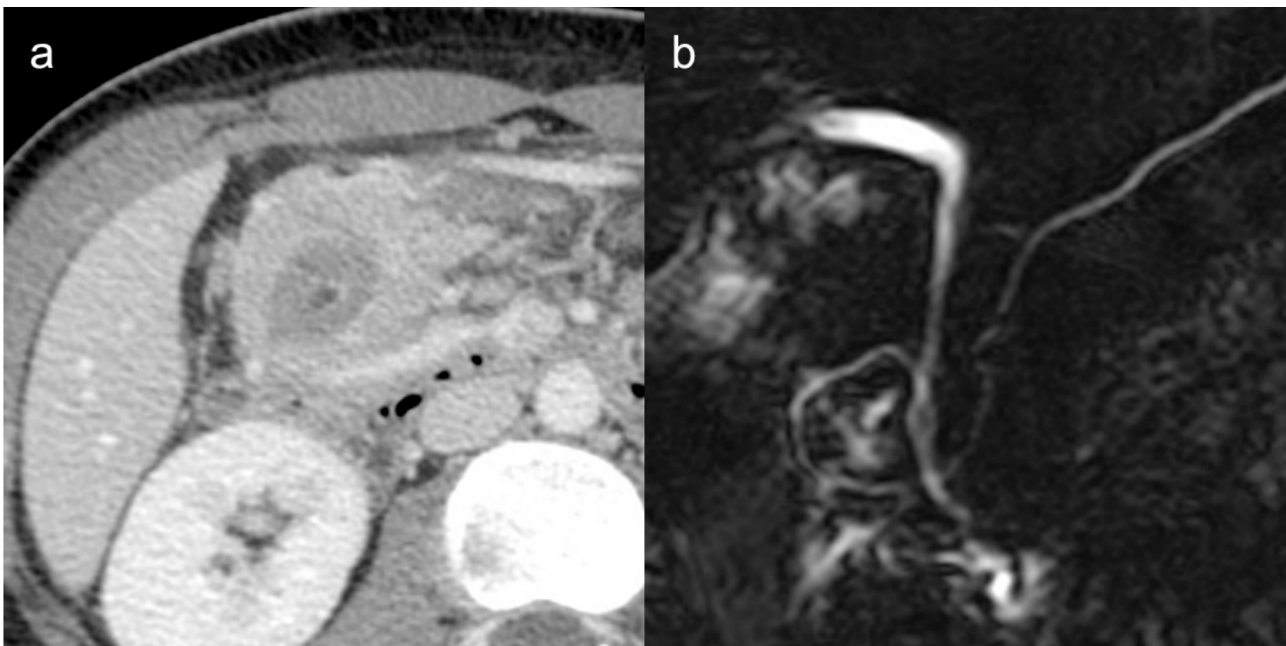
48-year-old male with annular pancreas. Contrast-enhanced CT (a) show the pancreatic parenchyma surrounding the second segment of the duodenum. MRCP (b) demonstrates the main pancreatic duct encircling the duodenum.
